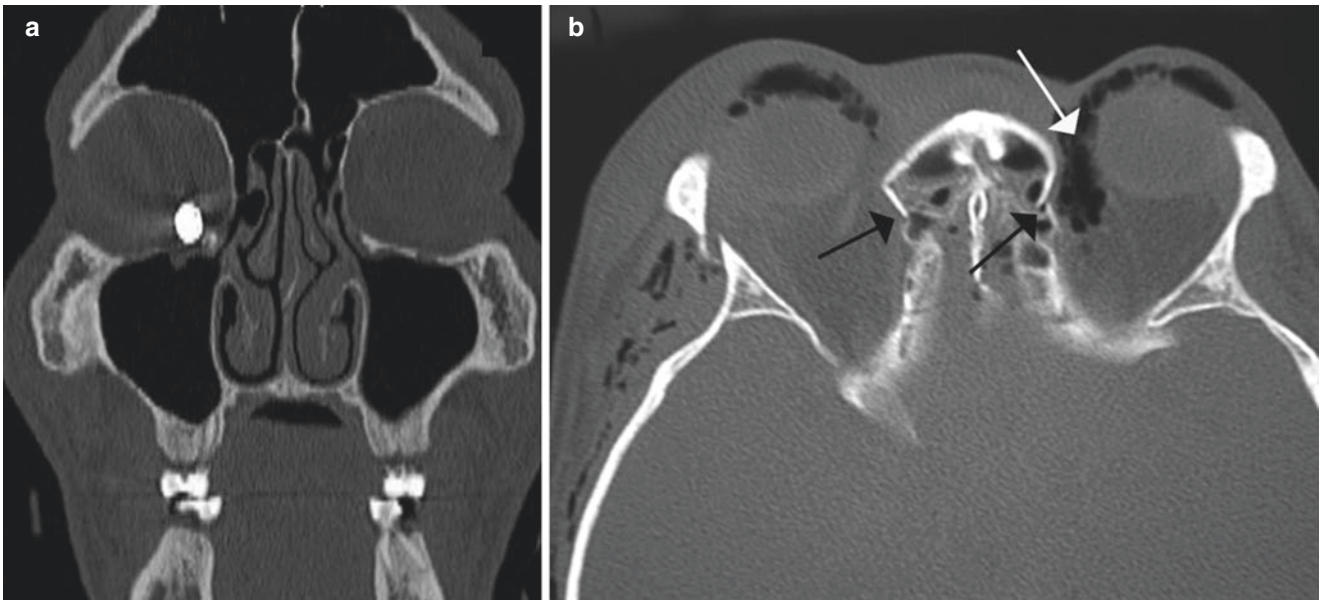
(a) Coronal CT showing an intraorbital foreign body. (b) An axial CT scan with the black arrows showing the naso-ethmoidal fracture and the white arrows showing air in the orbit
